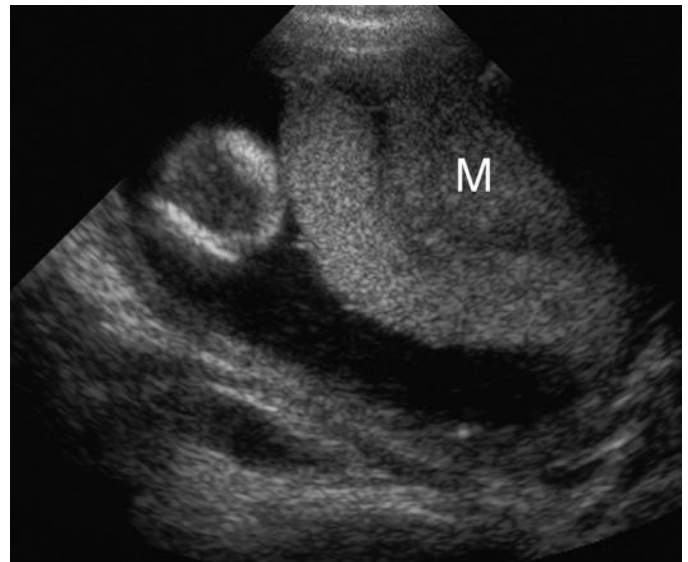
A myometrial contraction (M) is common in first and second trimester sonograms. This should not be confused with a myoma. Two features help make this distinction: First, in general, myometrial contractions tend to bulge inwardly without affecting the outer contour of the uterus. Uterine myomas tend to bulge inward and outward. Second, myometrial contractions may resolve during the time of scanning.
